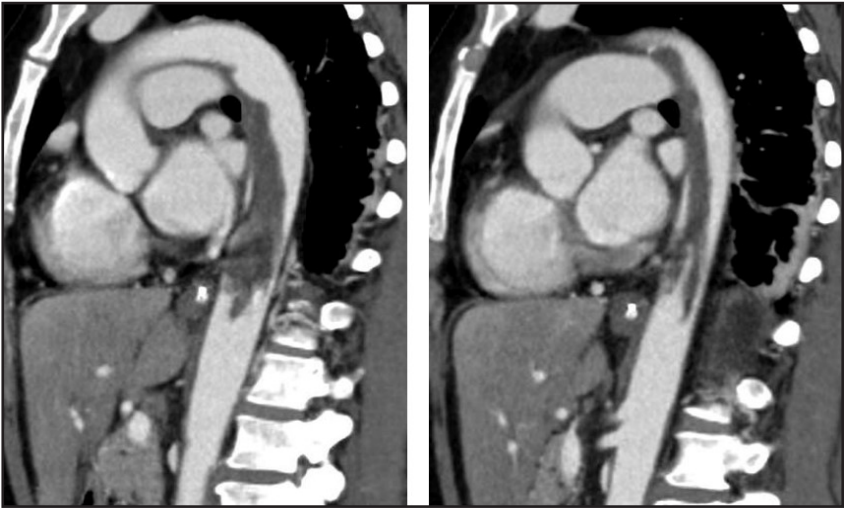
CTA of Thoracic Aortic Thrombus.
